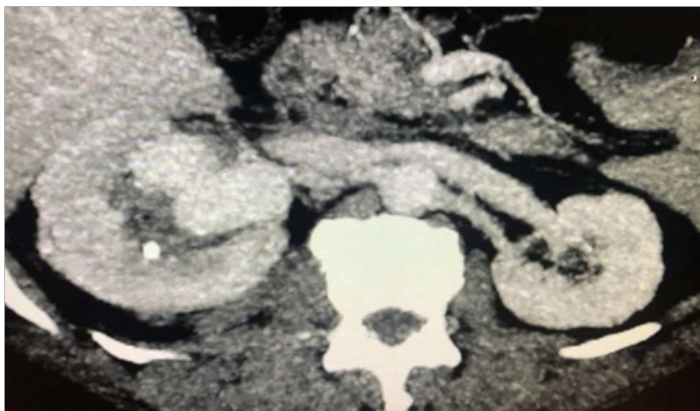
Computed Tomography of the Abdomen and Pelvis with Endovenous Contrast Showing Pseudoaneurysm of a Ruptured Right Renal Artery (Axial View).
